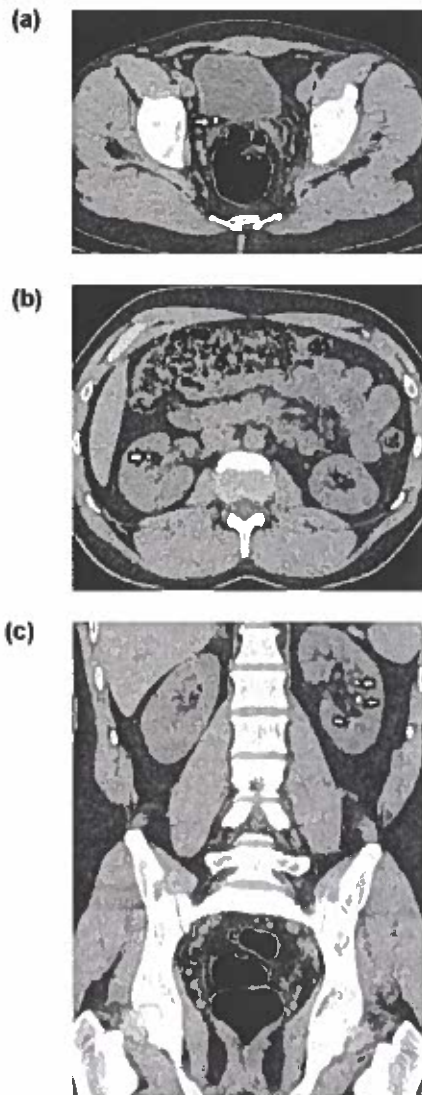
Ureterolithiasis with absence of acute obstruction. (a) Axial non-enhanced CT image of the lower pelvis shows a 2.5x3.5 mm stone (arrow) in the right ureterovesical junction. The mean CT density of the calculus is 350 HU. (a) Axial and (b) coronal reformations depict absence of right hydronephrosis. Bilateral small renal calculi (arrows) are found to coexist.
